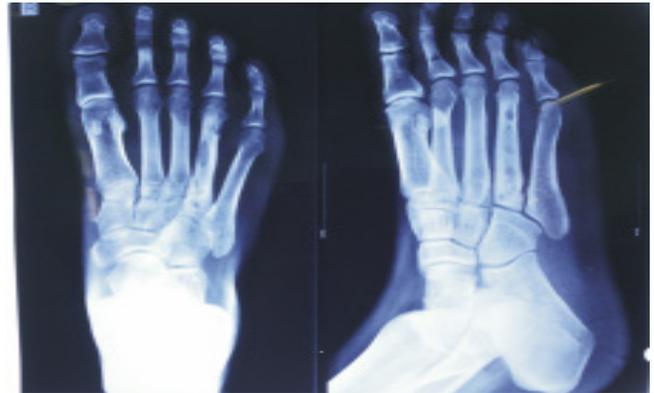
Chronic Osteomyelitis of the 4th metatarsal as seen on X-Ray
